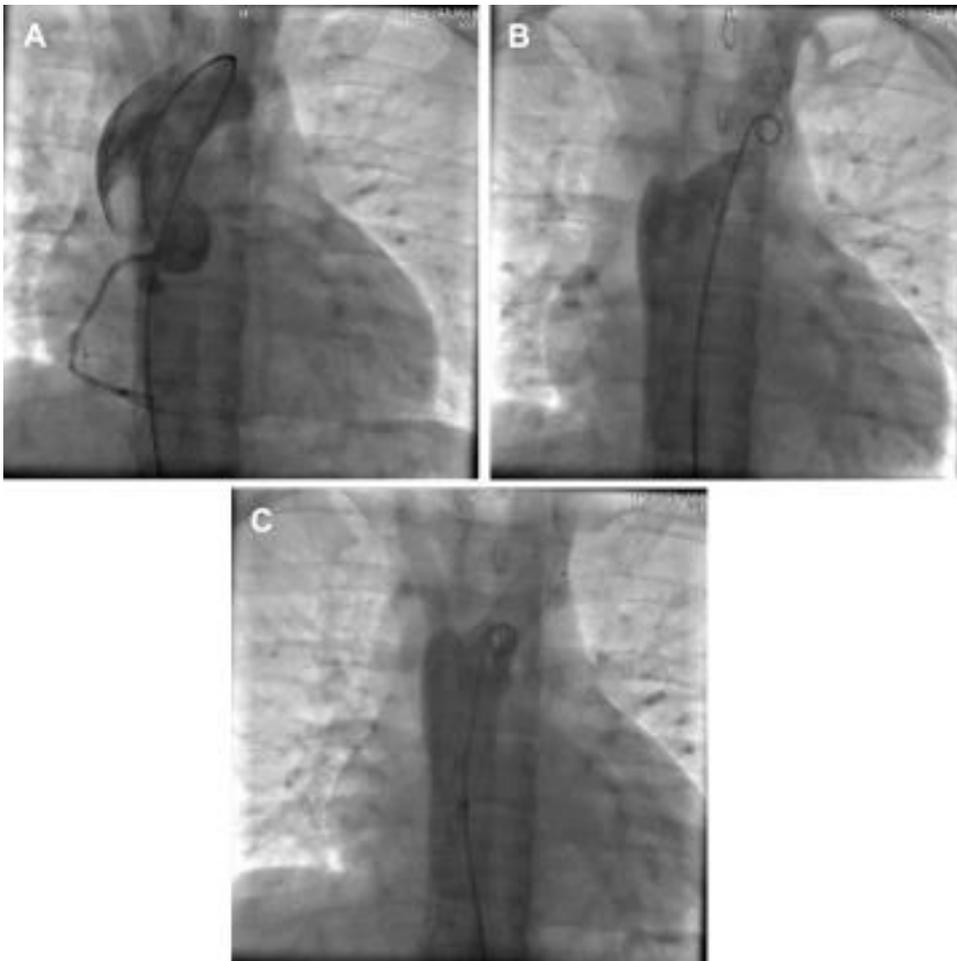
Radiographic images showing (A) wiring of the aorta, (B) pigtail catheter insertion to the coarctation site, and (C) stent placement and expansion in the coarcted area.
